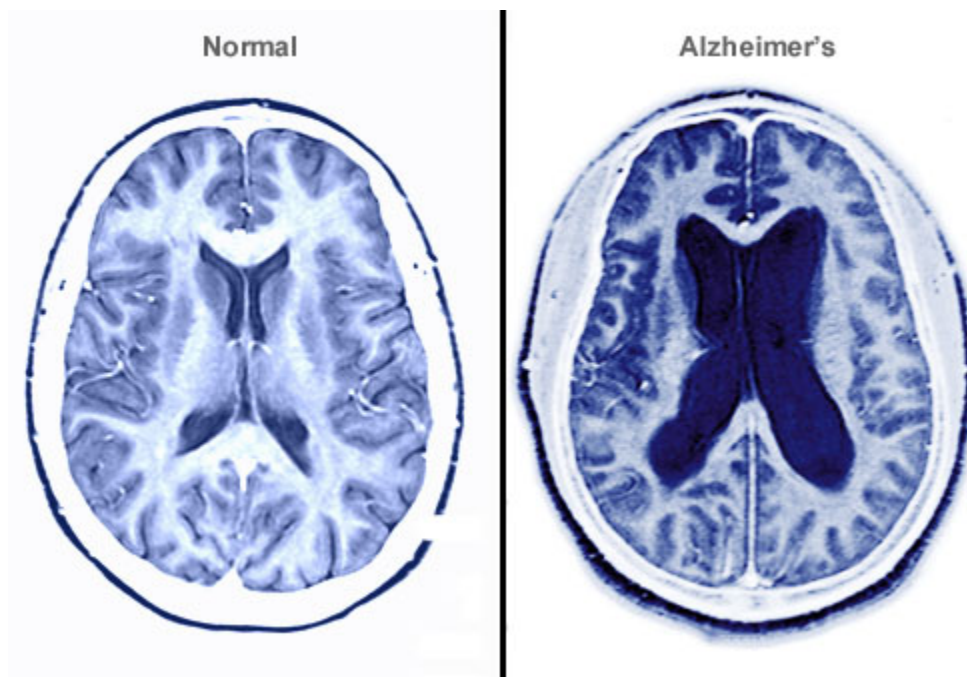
Comparison of MRI images of normal brain with AD brain (Image source:
